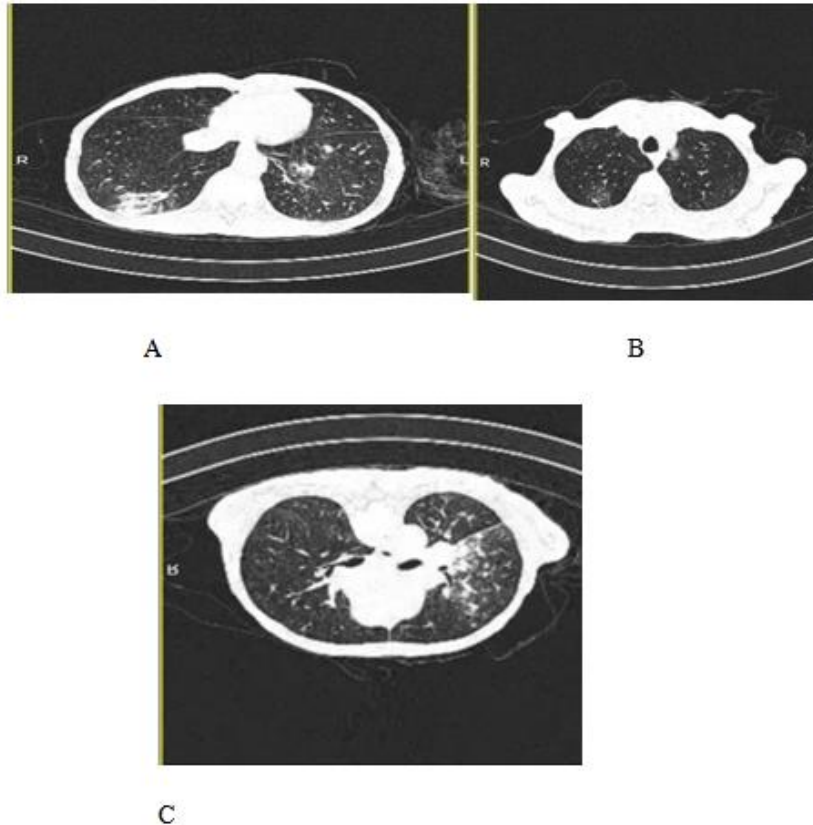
(A)(B) High-resolution CT (HRCT) of the thorax (lung window) on presentation area of patchy consolidation and area of ground glass opacity in both upper lobe and postero-basal lobe. (C) HRCT of the thorax (lung window) on presentation showing hyperinflation with centrilobular emphysema in both upper lobe
